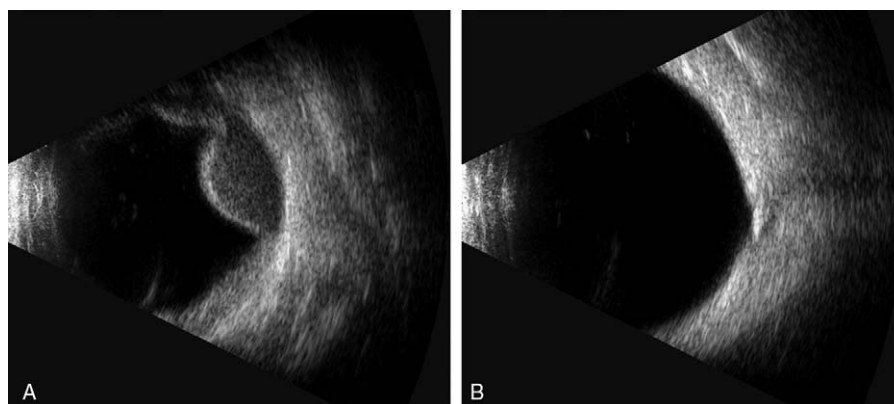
B-scan (A) The 2nd day postsurgery, the B-scan ultrasound indicated the features of choroidal hemorrhage. (B) After 1 month of treatment, the B-scan confirmed complete resolution of SCH. SCH = suprachoroidal hemorrhage.
